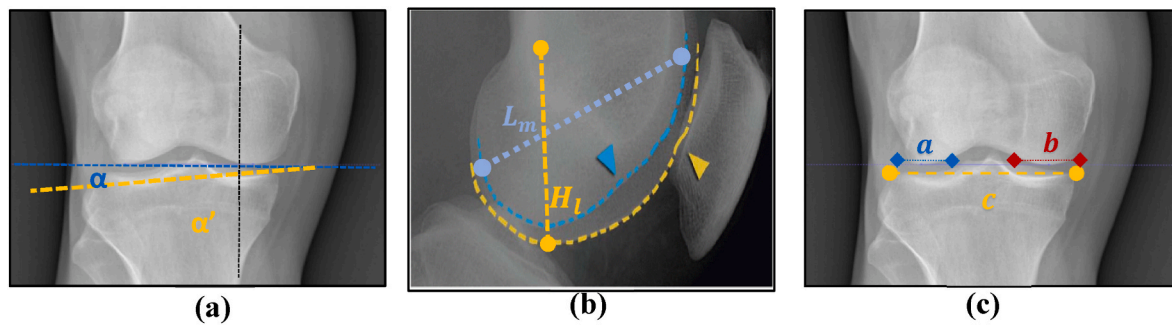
A view of personalized geometries obtained from radiographic images of subjects. 1.a: Calculating the tibial plateau tilt (TPT) from the radiographic images of the subject's knee joint 1.b: Calculating the Cam effect (CE); 1.c: Calculating the tibial plateau coverage by femoral condyles (TPCFC).
